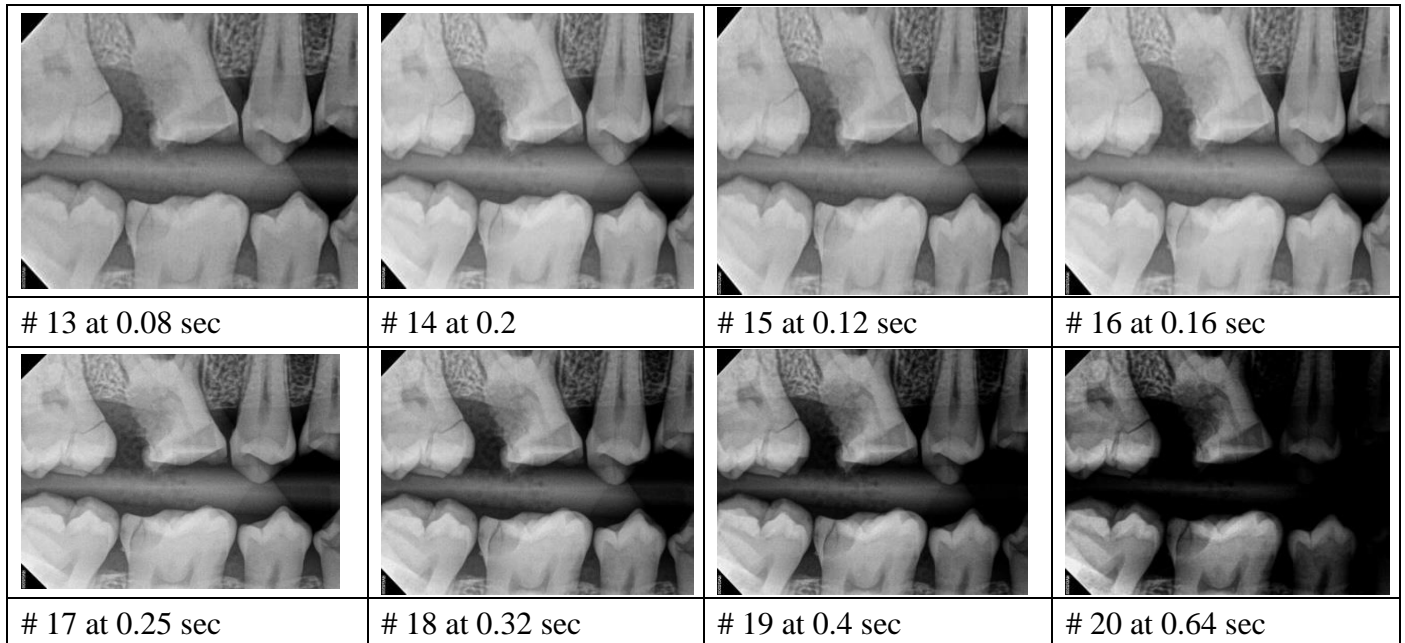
Image quality assessment has taken at different exposure time's and 50 cm SID using RVG 5200 sensor for bitewing projection.
